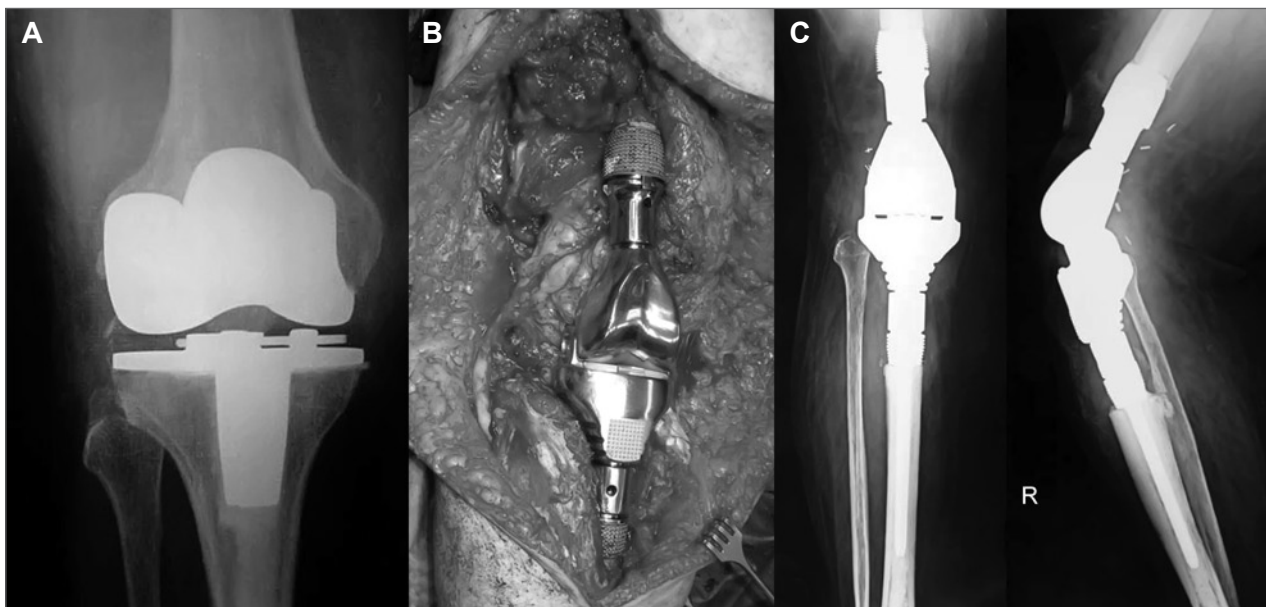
A: Radiograph of the right knee of a 69-year-old woman with synovial sarcoma of the knee initially misdiagnosed as arthritis (Patient 23). B: Extra-articular resection and C: reconstruction using a megaprosthesis knee joint was done; 14 months postoperatively, the patient is alive with no evidence of local recurrence or distant metastases.
